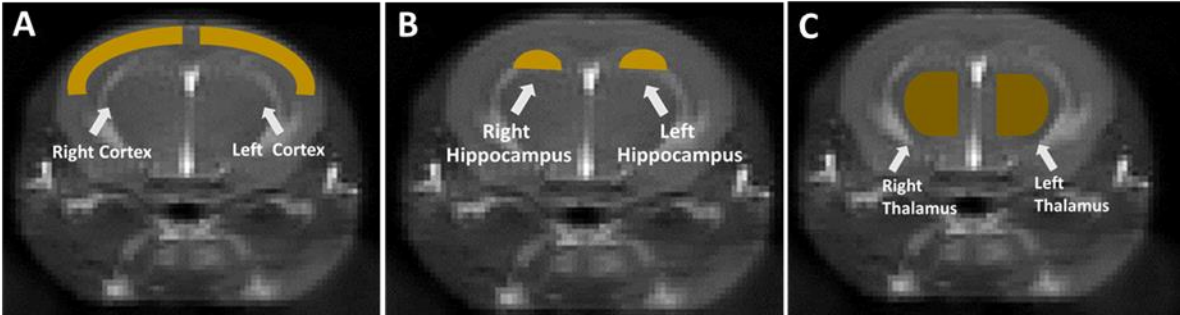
Brain regions of interest selected for MRI data analysis.
